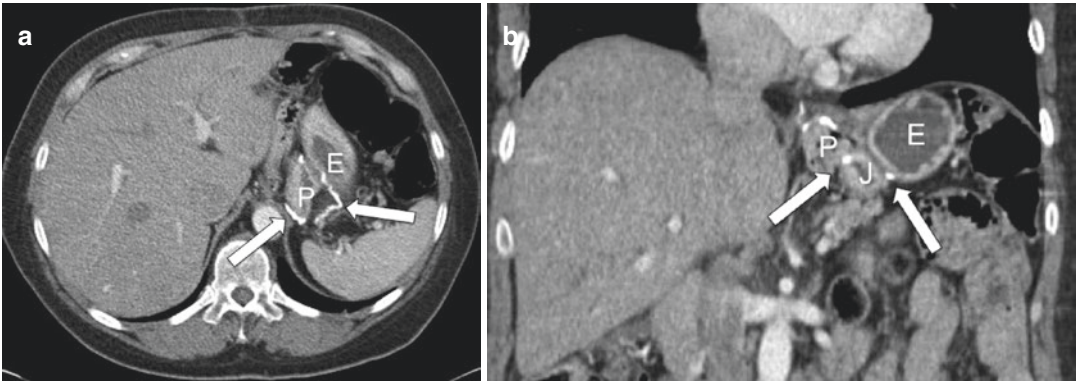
(a) Axial and (b) coronal CT showing normal post operative appearances with clear and intact staple lines between the excluded stomach (E) and the gastric
